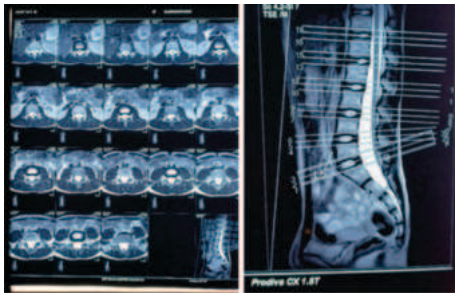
a and 4b, MRI LS Spine Showed Low Lying Conus Medullaris At L5 - S1 With Cord Tethering At L5- S1. Wide Spinal Canal From L3 To Upper Sacral Levels.
